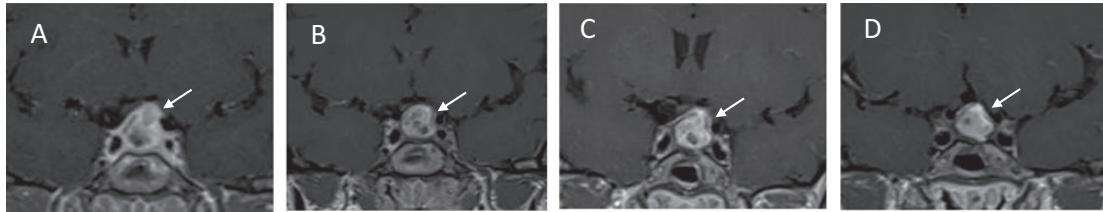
Coronal postcontrast T1W MR images of the pituitary. A: Image at presentation showing a sellar and suprasellar mass lesion involving the pituitary stalk and compressing the optic chiasm and involving the left optic nerve. B: Image following a short period of GC treatment and the first cycle of RTX. C: Image following the second cycle of RTX. D: Image following the third cycle of rituximab. Serial images demonstrate gradual reduction of the left-sided suprasellar component and some decompression of the left optic nerve (white arrows). There is been no significant overall reduction in the size of the pituitary mass lesion.
